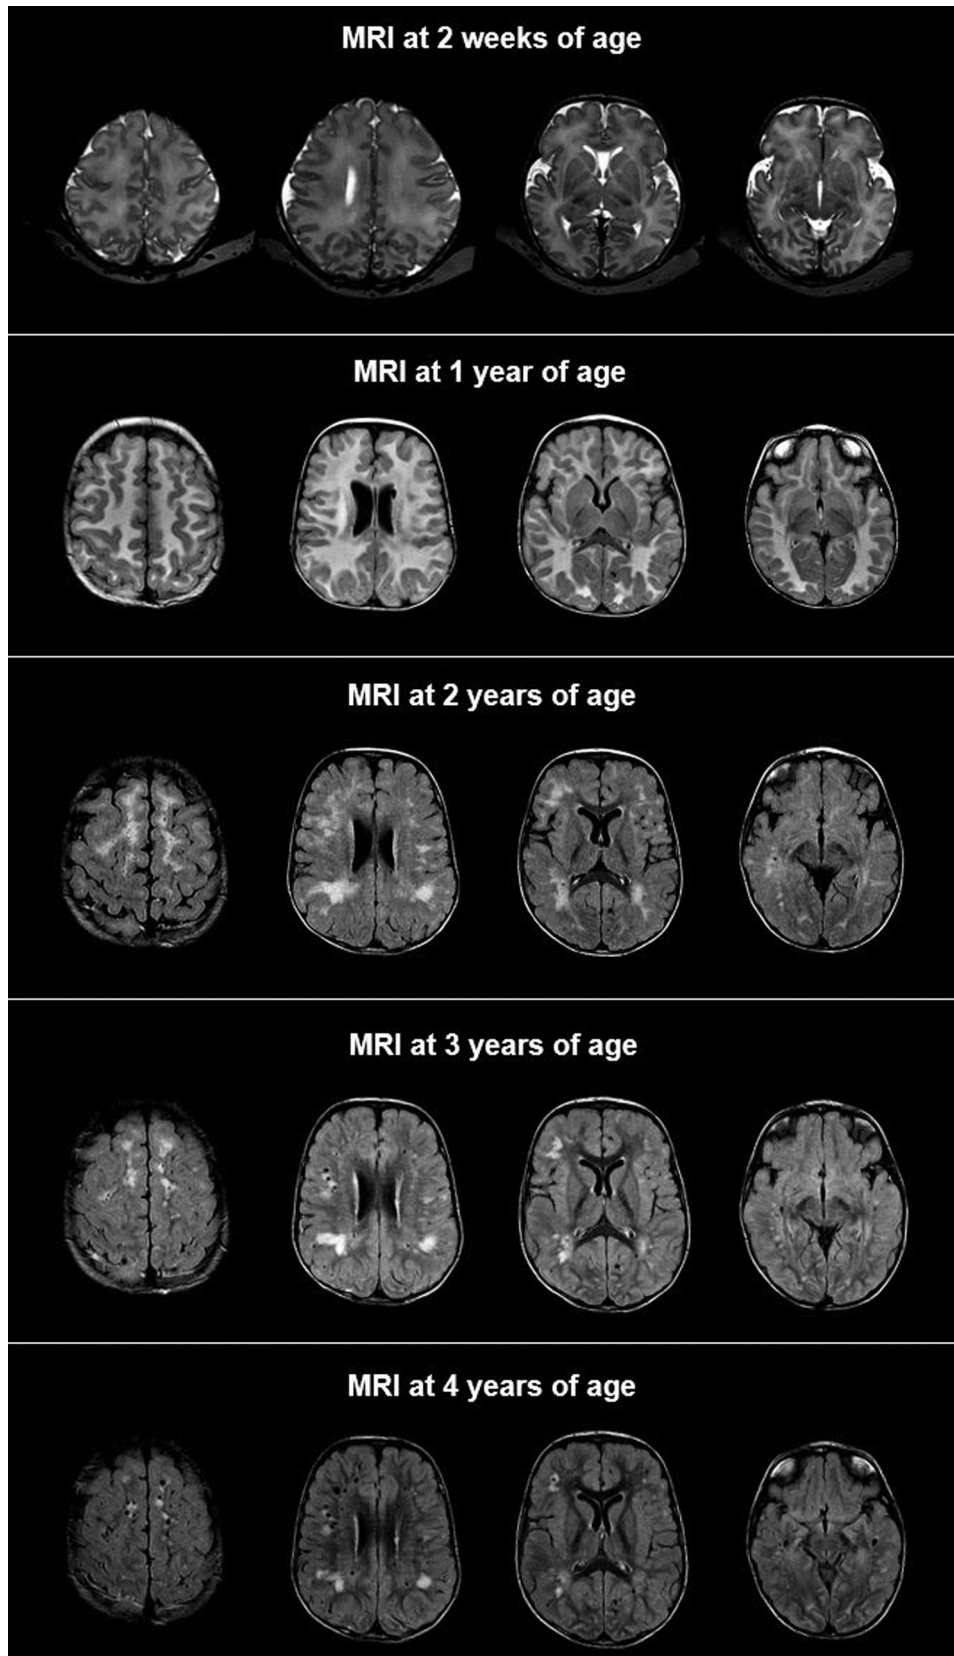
Serial axial T2 fluid-attenuated inversion recovery magnetic resonance imaging showing diffuse bilateral supratentorial white matter abnormalities at birth, reaching its nadir and involving almost the entire supratentorial white matter around age one year and then gradually improving over years with development of prominent perivascular space.
